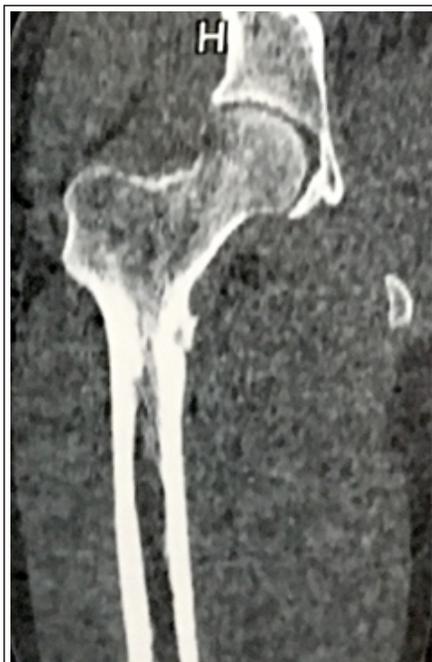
Computed tomography image showing pre-operative coronal section focal hyperdensity in the small right femoral trochanter.
